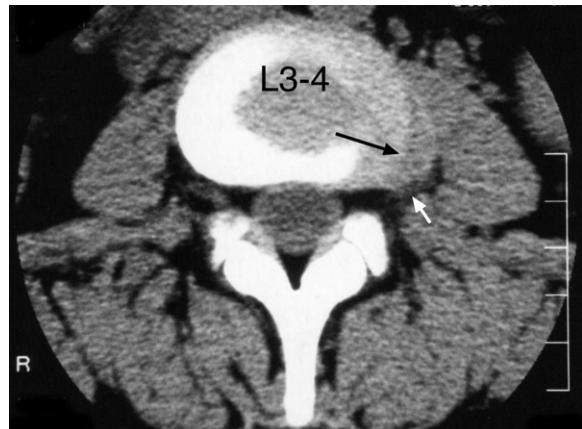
CT axial image at the L3–4 level showing the far lateral left sided disc protrusion (long black arrow) beyond the exit foramen; the protrusion distorts the path of the L3 nerve (short white arrow).
